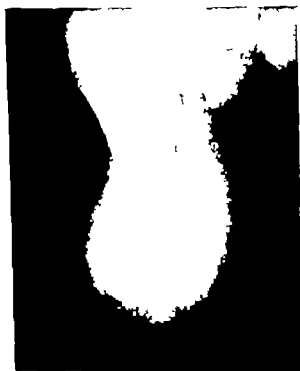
Roentgenogram showing recurrence of osteogenic sarcoma in an amputation stump. This complication is not observed with sufficient frequency to justify routine disarticulation at the hip for tumors in the lower femur.
